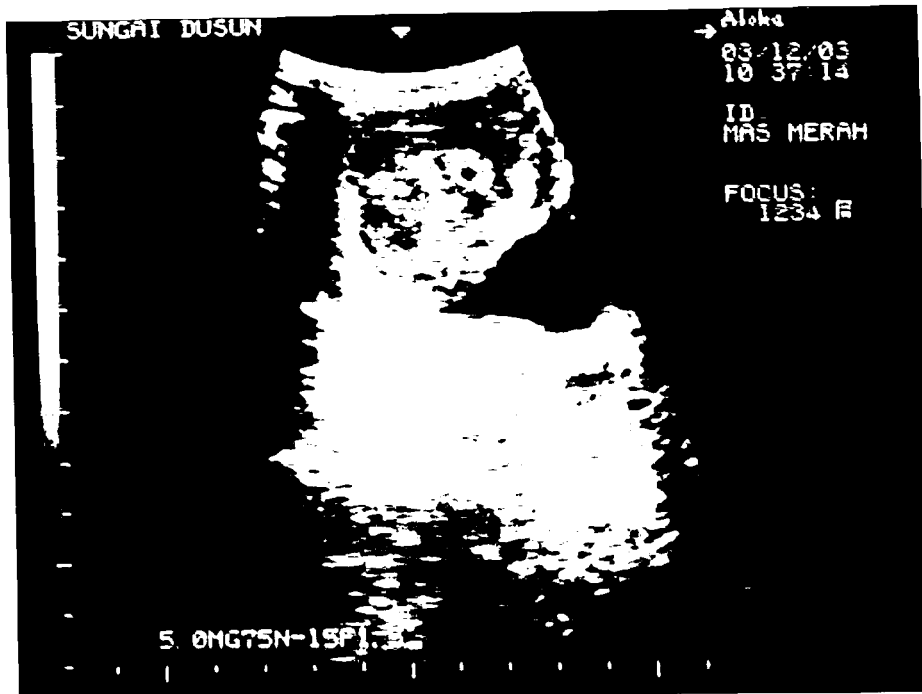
Ultrasound image of palpable mass located at the base of Mas Merah's right uterine horn (arrow). A similar mass was observed on the adjacent uterine horn.
